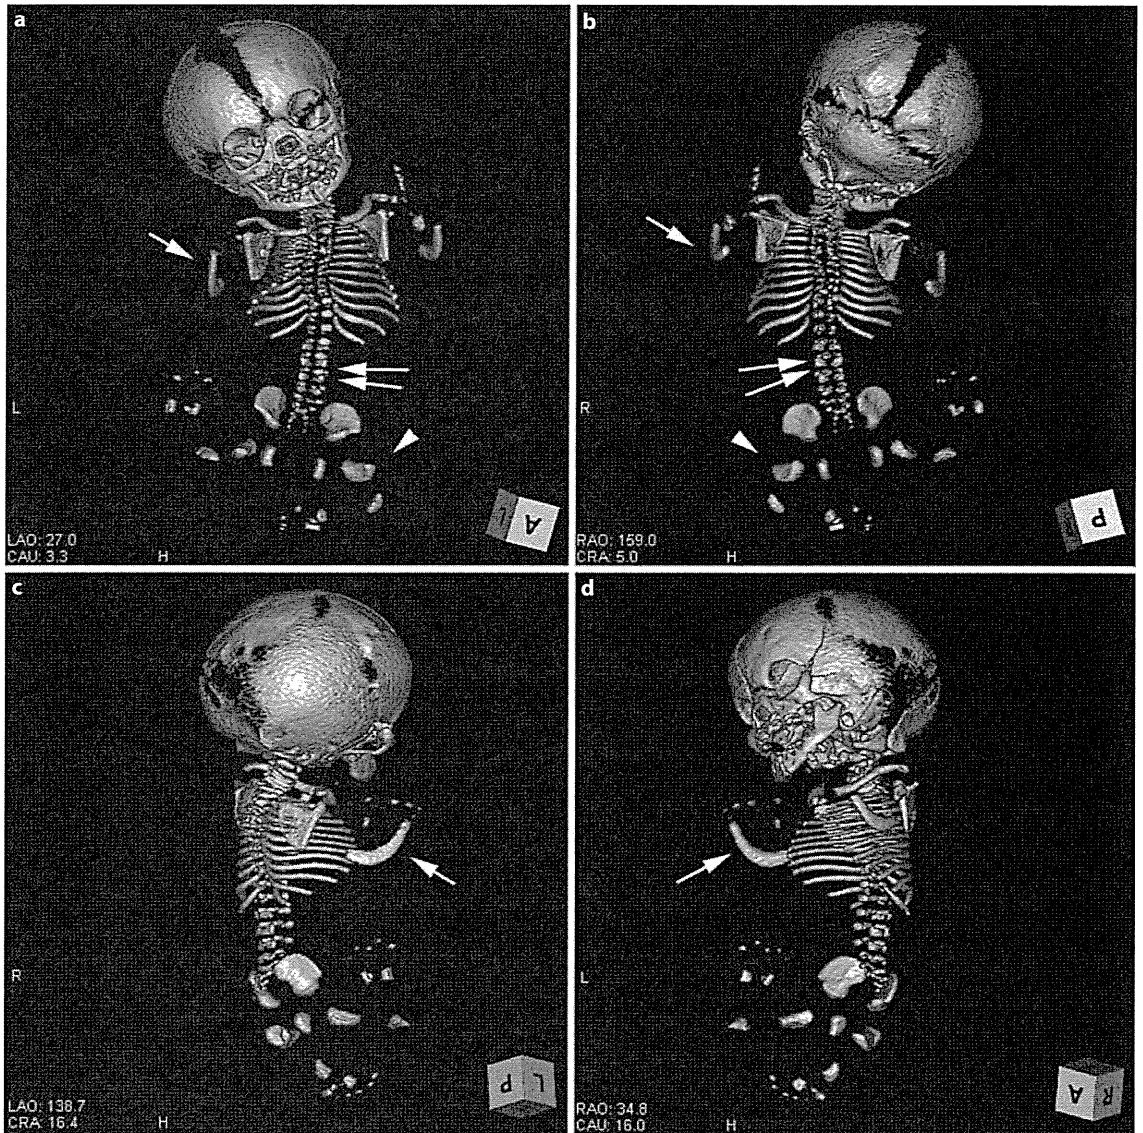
3D-CT views showing the boomerang-like shaped ulna (white arrow), the segment shaped femur (white arrow head) and zipper-like shaped spine (double arrows). The humerus and radius were absent: front view (a), rear view (b), right side view (c) and left side view (d).
